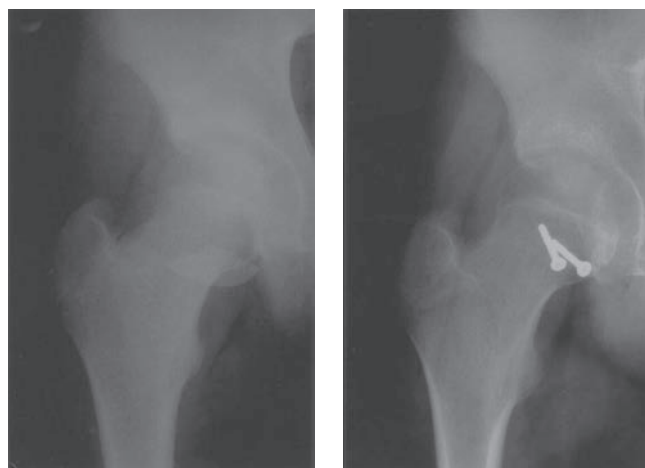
A: A posterior dislocation associated after reduction with a femoral head fracture caudal to the ligamentum teres (Pipkin type 2). This is uncommon in children. This was treated with open reduction and internal fixation, with follow-up radiographs taken 1 year after the injury (B).
